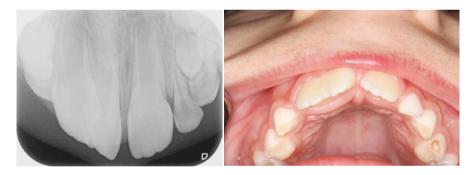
This periapical radiograph was taken to verify the true nature of the clinical finding of an unusual wide permanent maxillary right-hand-side central incisor. The crowns of the lateral and central incisors have fused, while the roots and pulp canals appear to be separate. Therefore the final tooth count is one too few (courtesy of Dr. Wouter Van den Steen, Belgium)
